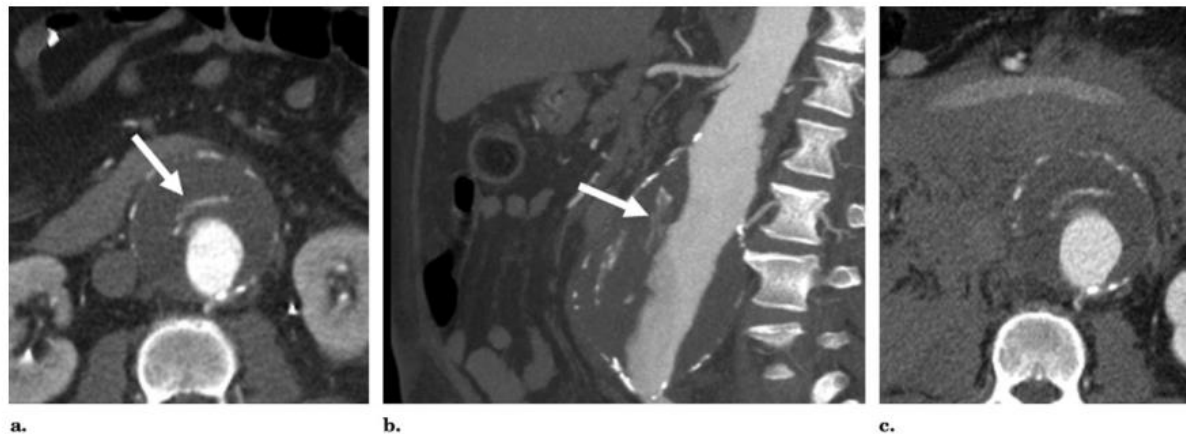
Contrast-enhanced CT scan of AAA with crescent, from [72]
